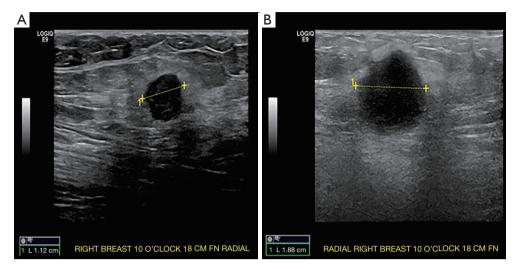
Ultrasound imaging before and after neoadjuvant treatment with T-DM1 for Patient 1. (A) Before: right breast 10:00 18 cm from the nipple is a 1.1 cm mass. (B) After: right breast 10:00 18 cm from nipple there is a hypoechoic mass now measuring maximally 1.8 cm previously measured maximally 1.12 cm. T-DM1, ado-trastuzumab emtansine.
